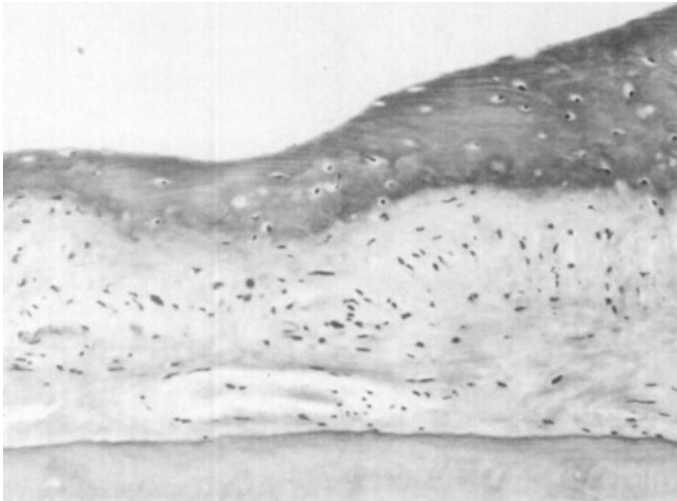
Ultrasonically cut alveolar bone during tooth extraction (reprinted from Horton et al. [90] with permission. © Elsevier)
